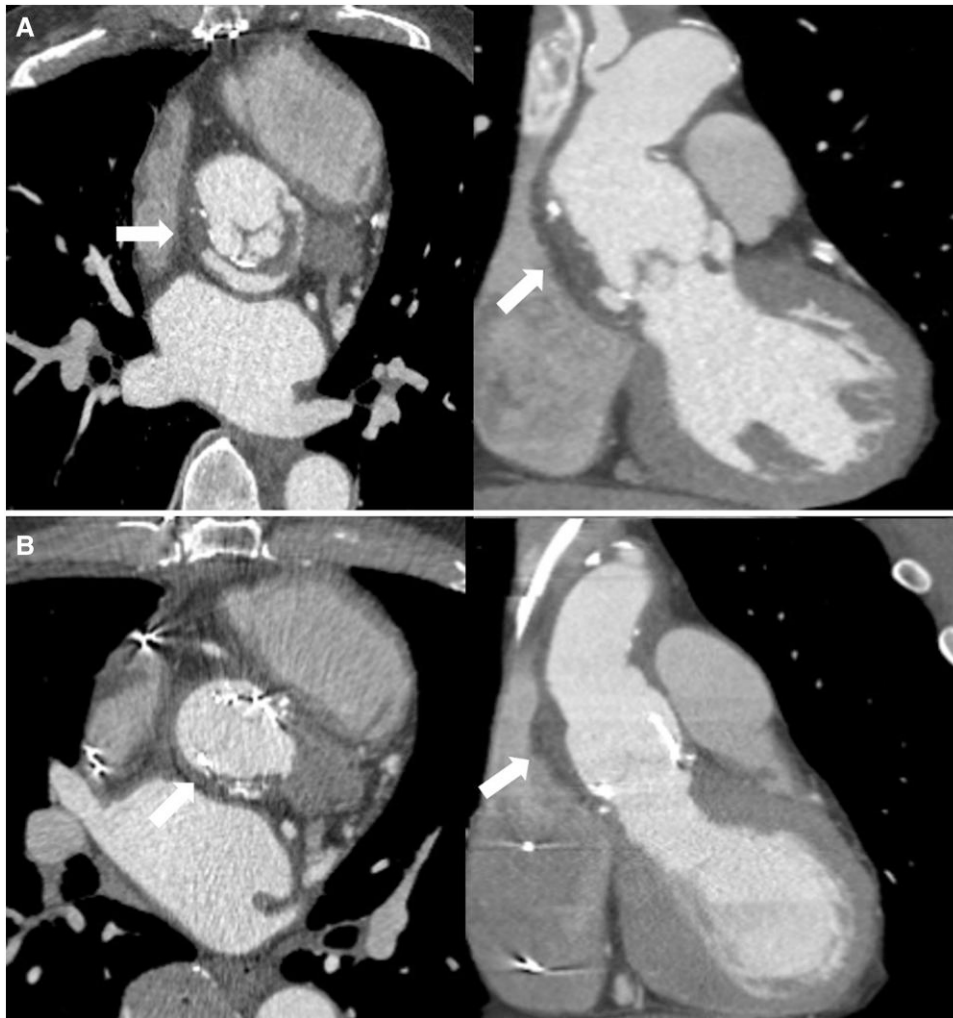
(A) Computed tomography scan performed prior to first re-do operation demonstrating abnormal contrast accumulation between aortic graft and native aortic tissue following modified inclusion root technique with nearby soft tissue density (white arrows). (B) Persistent soft tissue abnormalities with para-valvular calcifications following re-do total root reconstruction (white arrows). Findings are identical to computerized tomography performed during index hospitalization (Figure 1A).
